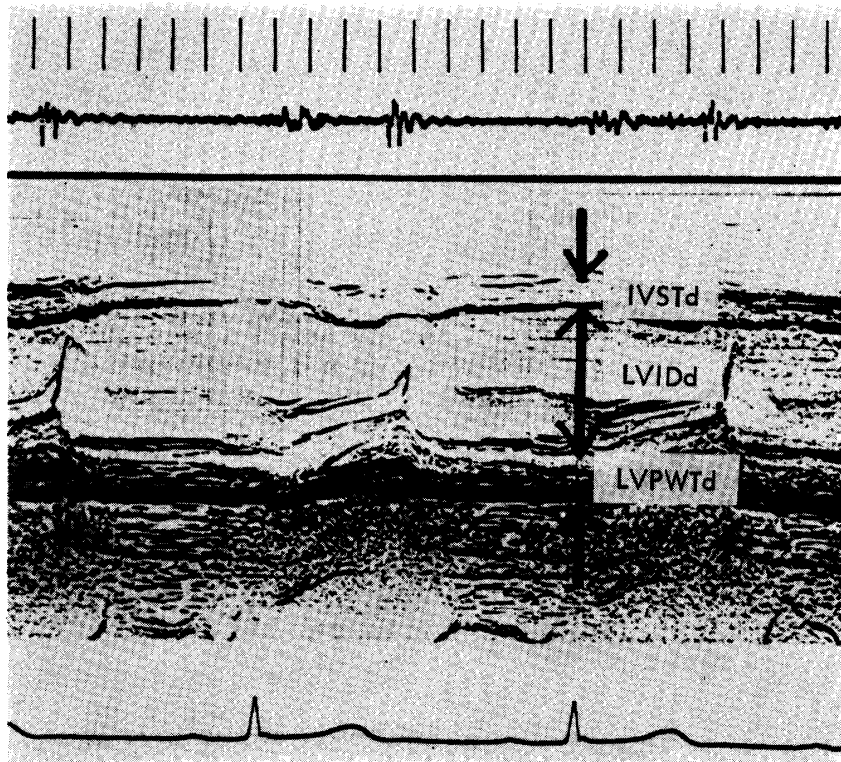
Echocardiogram with Case 5, 14-year-old girl with "borderline" hypertension (132/80). LVMV is markedly increased (145.8 ccm).
